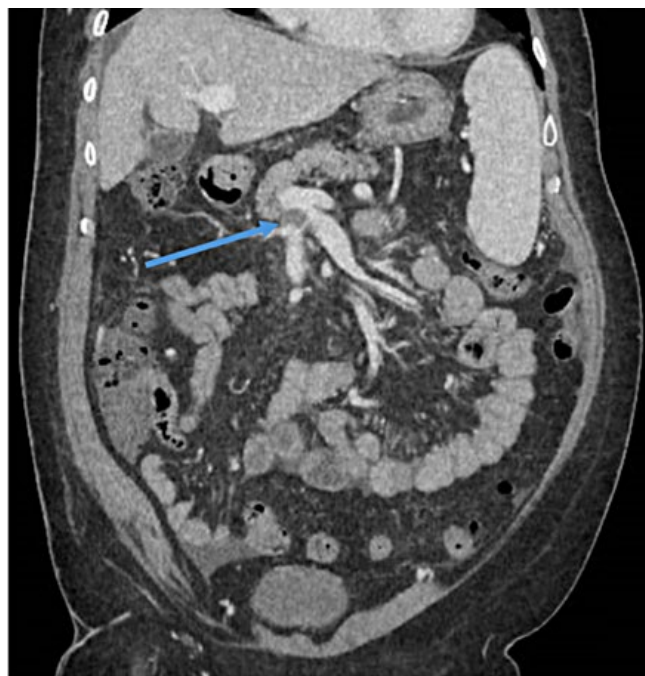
Abdominal and pelvic CT scan demonstrating partial thrombosis of the superior mesenteric vein (SMV) (blue arrow), contacting the origin of the portal trunk (blue arrow).
